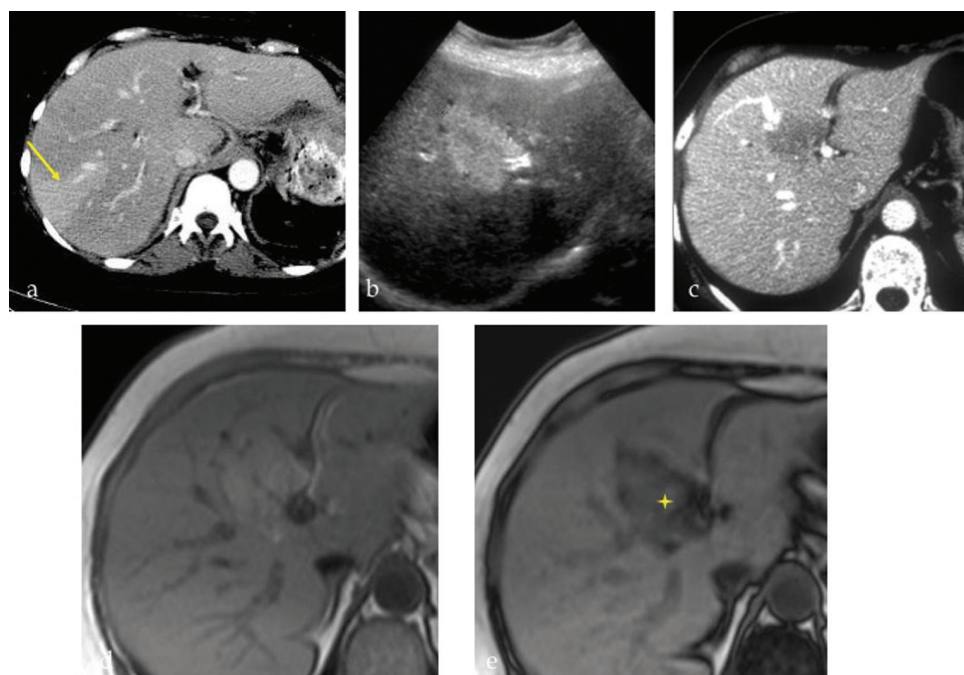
a. Transient hepatic attenuation differences – a peripheral wedge-shaped area of hyperenhancement with no mass effect. b. Focal fatty infiltration on ultrasound – a triangular echogenic lesion in periportal region. c. Focal fatty infiltration on computed tomography seen as a well-defined triangular area of low density. d. In and (e) out of phase magnetic resonance imaging with signal drop (star) on the out of phase indicating fat.
